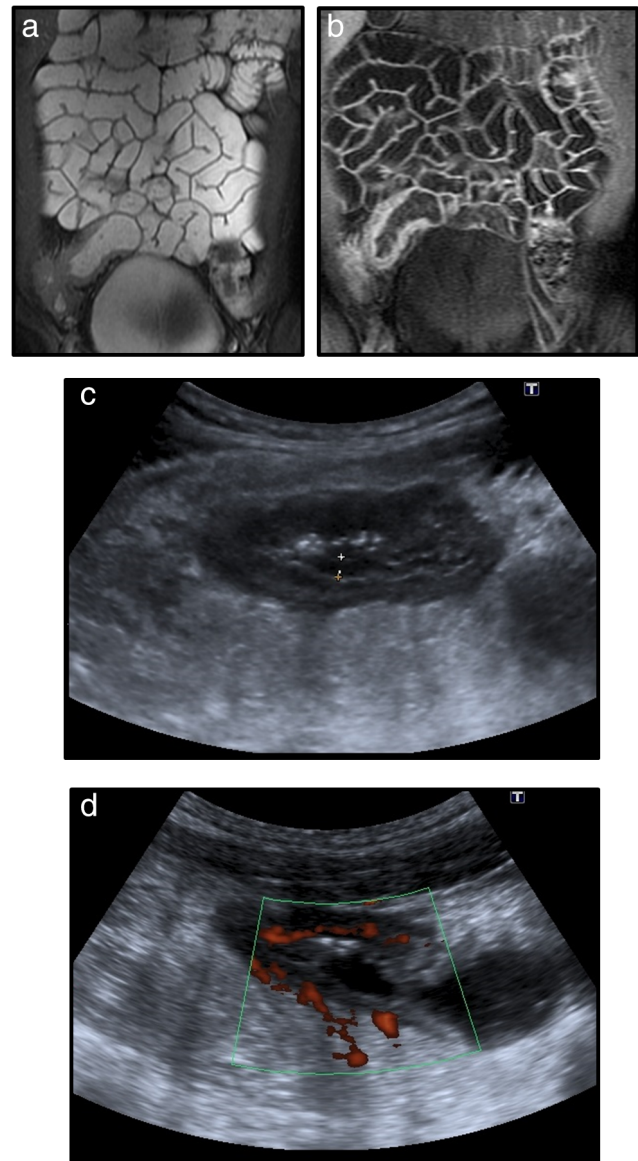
A 16-year-old male with Crohn's disease. (a) Coronal magnetic resonance enterography (MRE), gradient Echo (GRE) sequence (2D FIESTA), demonstrating bowel wall thickening affecting the terminal ileum, caecum, and appendix. (b) Coronal MRE, 3D, T1-weighted sequence with fat suppression and intravenous gadolinium contrast administration (LAVA) at 70s postinjection, demonstrating avid enhancement of the thickened segment of bowel. (c) Selected small intestinal contrast ultrasonography (SICUS) images demonstrating the same loop of terminal ileum, with bowel wall thickening and edema (hypoechoic change), decreased luminal diameter, and (d) increased vascularity on Doppler imaging.
